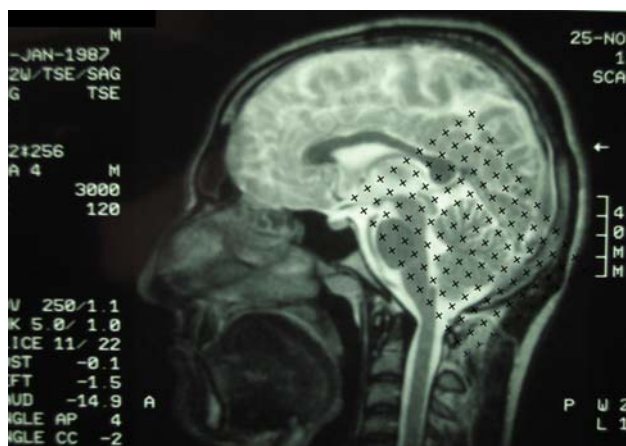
A sagittal MRI scan with a point counting grid superimposed on it for the estimation of CV
